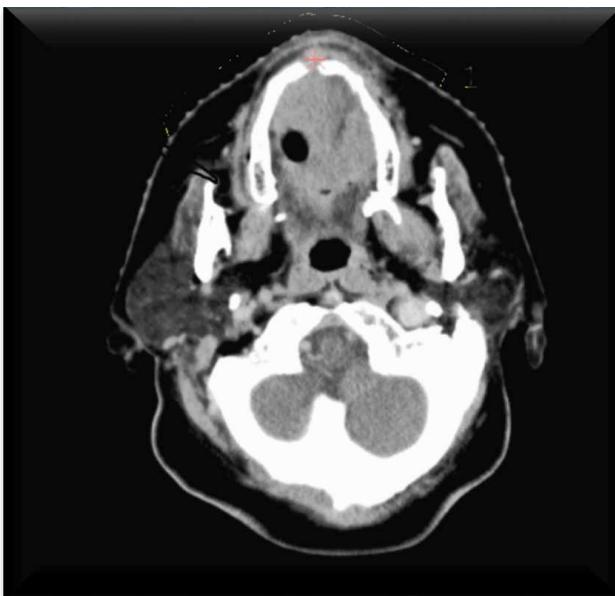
Clinical picture and CT presentation
